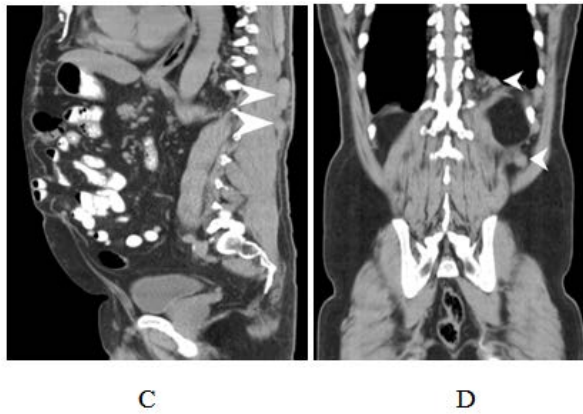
Non-enhanced abdominal CT Sagittal (C) and Coronal (D) images
